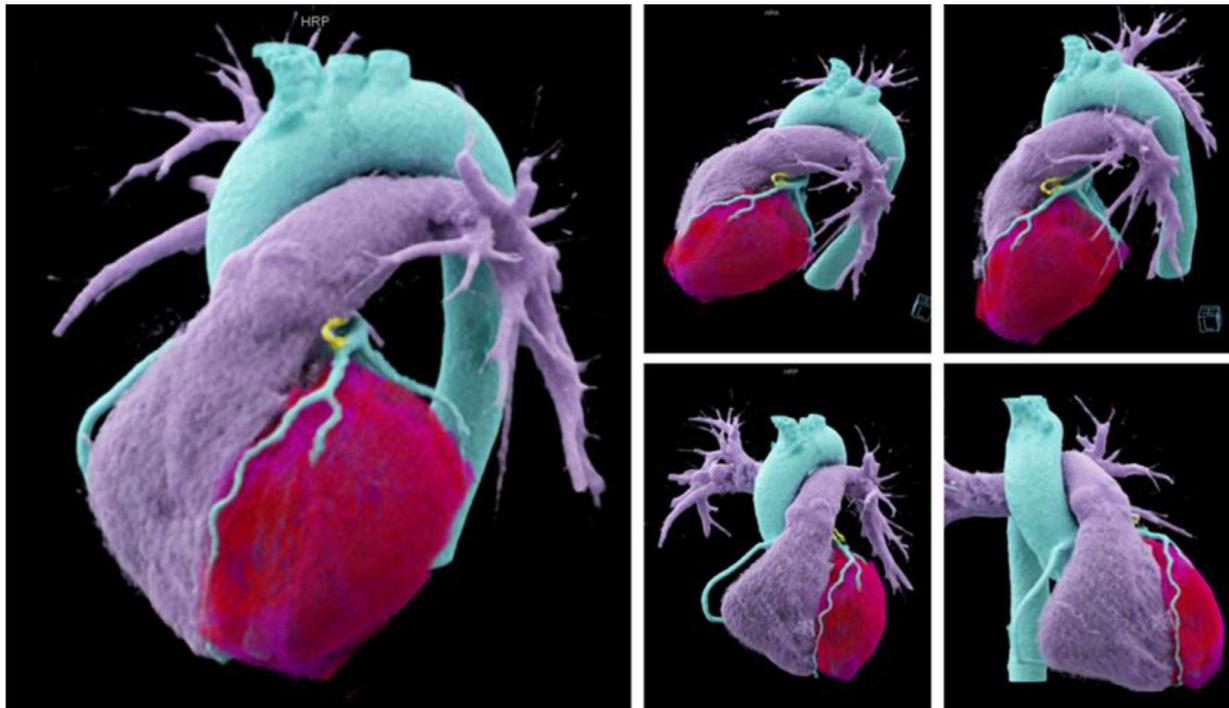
The 3D cinematic rendering reconstruction of the CT dataset demonstrates the small caliber fistula connection between the left coronary artery and the main pulmonary artery (yellow vessel) with an averaged diameter of 1.3 mm.
